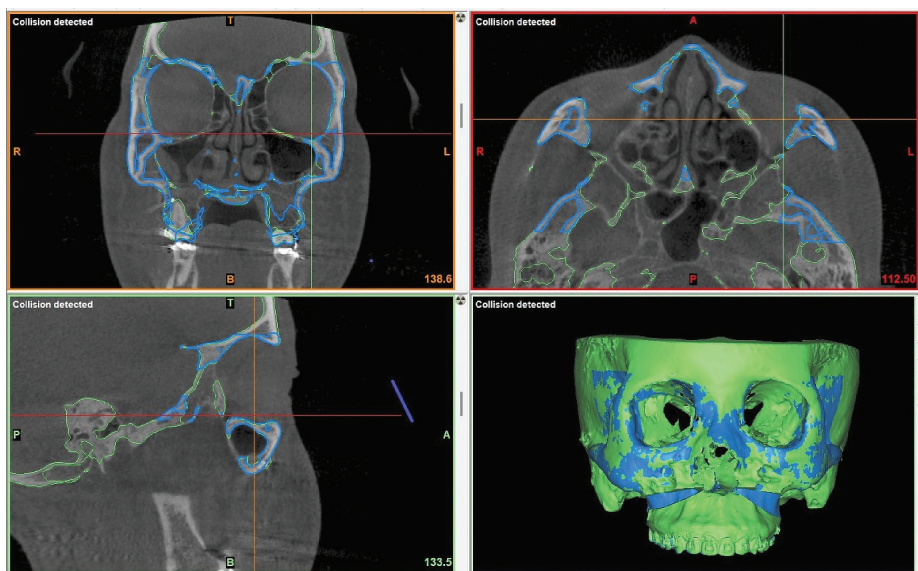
Superimposition of postoperative CBCT (Converted to STL file) and surgical virtual planning (STL file)
